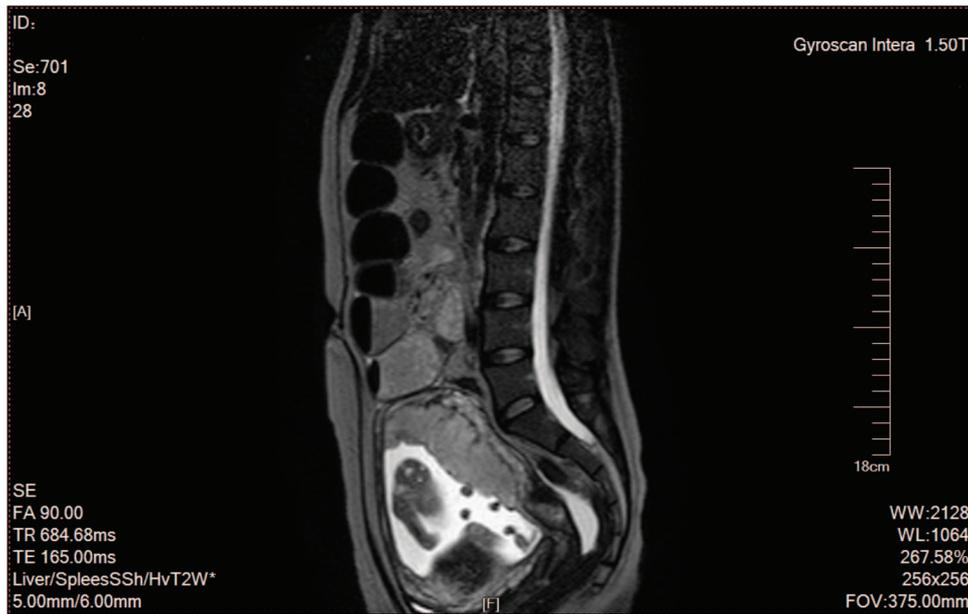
Abdominal magnetic resonance imaging showed intraperitoneal bowel expansion with effusion.
